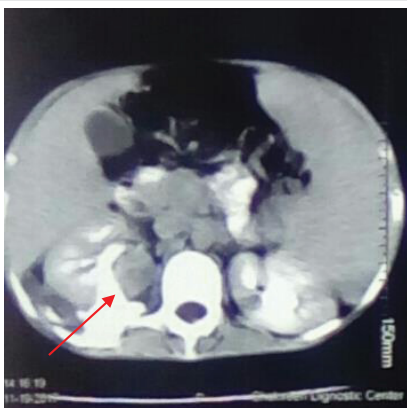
CT urography showed grade 4 renal injury with extravasation of the contrast (Red arrow).
